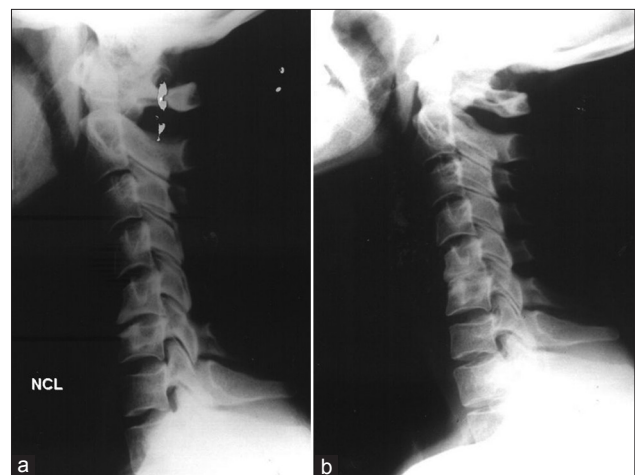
(a) Preoperative X-rays of a patient submitted to C5-C6-discectomy. Autografting was performed due to significant osteophytes removal. (b) Postoperative 2.5 months control shows improved spine alignment
